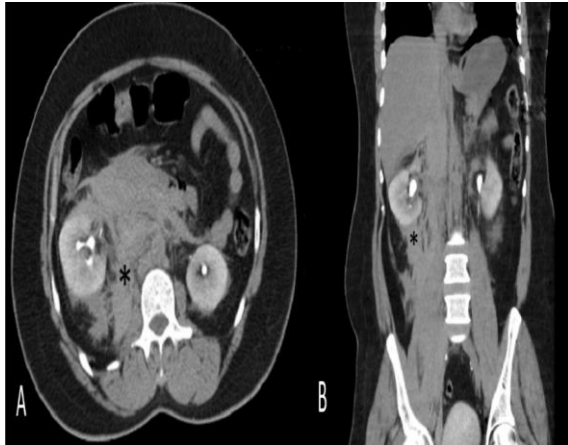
CT scan of the abdomen (A) axial and (B) coronal showing retroperitoneal hematoma in right perinephric, anterior pararenal space and surrounding the right kidney along its anteromedial and posterior aspects, being in contact with right psoas major muscle.
